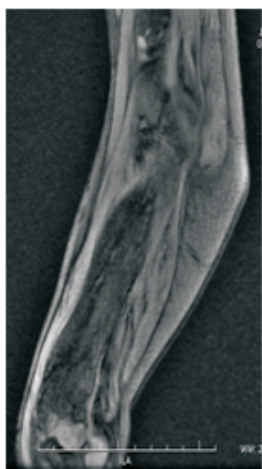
Sagittal T2 weighted MR image shows heterogeneously low signal intensity consisting with the fibrous matrix in femur.
